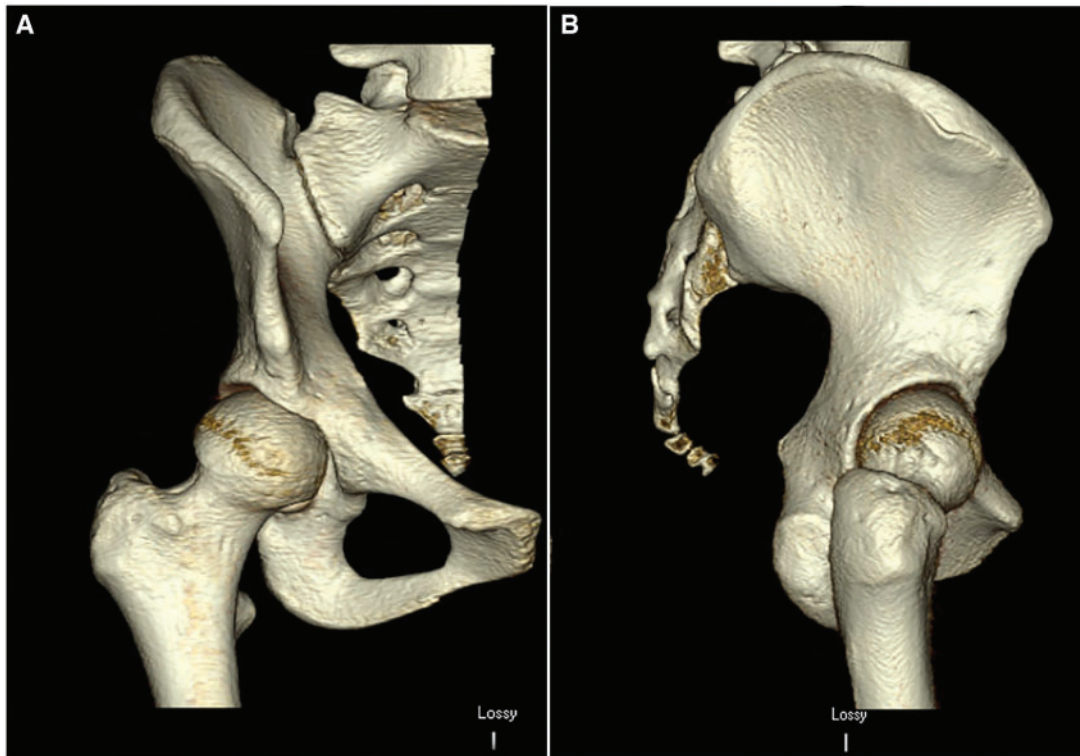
(A) Coronal 3D CT scan and (B) Sagittal 3D CT images of a 28-year-old female patient with right hip dysplasia—showing combined anteversion of the acetabulum and femur, resulting in an area of anterior undercoverage.
